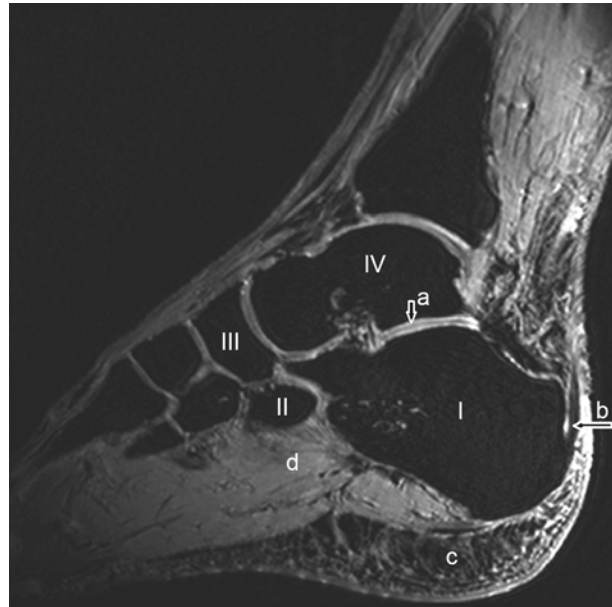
Sagittal MR image of tarsal bones. Fat suppressed 3D T1 weighted gradient echo sequence with selective water excitation. Calcaneus (I), cuboid (II), navicular (III), talus (IV), and cartilage (a), Achilles tendon (b), heel fat pad (c), musculus quadratus plantae (d).
